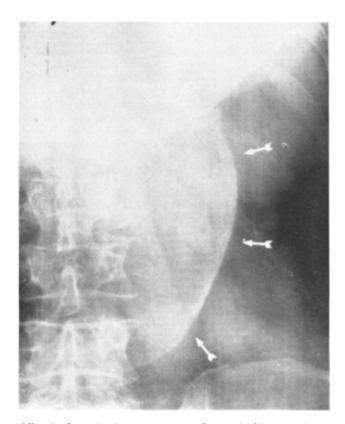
Case 2. Demonstrates a large fusiform abdominal aneurysm in a preliminary roentgenogram made in the supine position. The sac extends from the 12th dorsal vertebra to the 4th lumbar vertebra (retouched). Note the psoas muscle is clearly visible.
